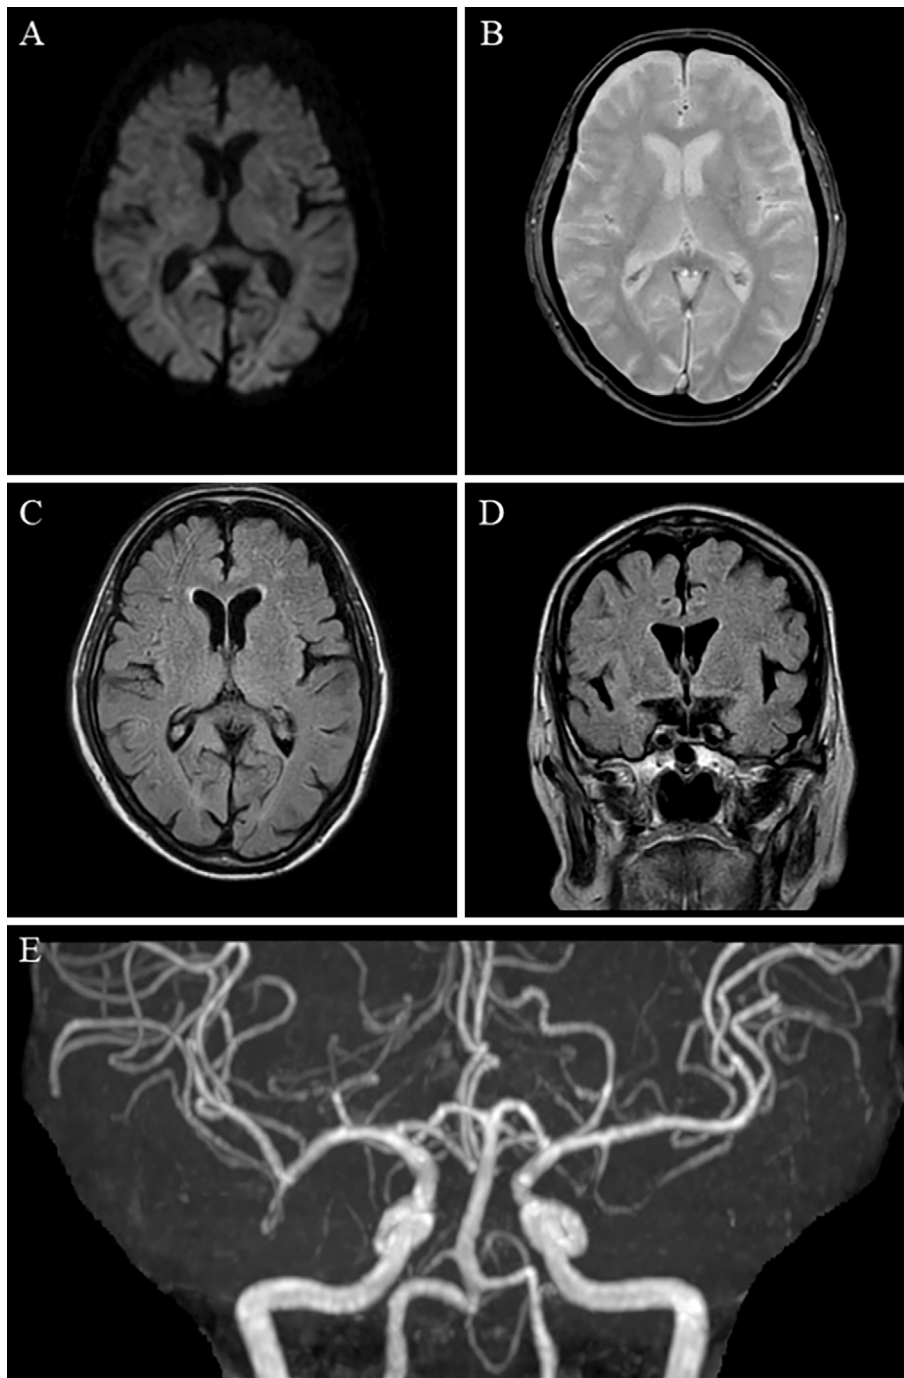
Findings from magnetic resonance imaging (MRI) of the brain on admission. Diffusion-weighted imaging (A) and T2*-weighted imaging (B) show no signal-intensity abnormalities. Fluid-attenuated inversion recovery (C, D) shows neither edematous changes in the brain nor ventricular enlargement. Three-dimensional time-of-flight magnetic resonance angiography shows arteriosclerotic change (E). Contrast-enhanced MRI was not performed due to the renal function being reduced by chronic kidney disease.
